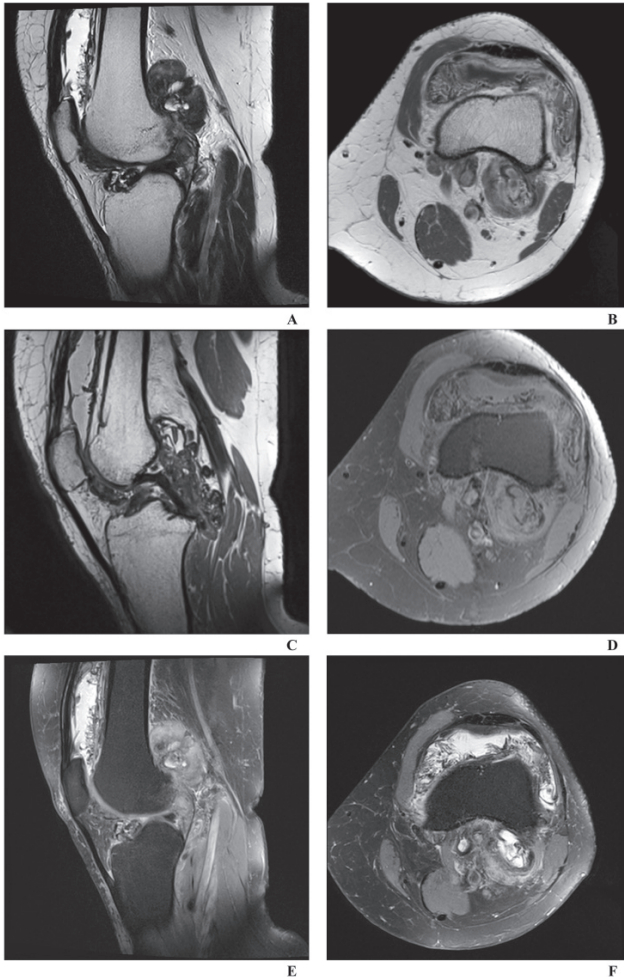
Pigmented villonodular synovitis, localized type of the knee joint. Sagittal (A, C, E) and axial images (B, D, F) in T2- (A), T1-weighted (B, C) and T1-weighted with fat saturation (D) and T2-weighted with fat saturation (E, F).
